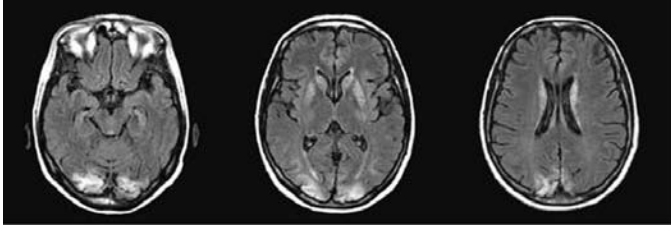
FLAIR MRI image showing bilateral occipito-polar damage and bilateral hyperintense signal in the basal ganglia.
